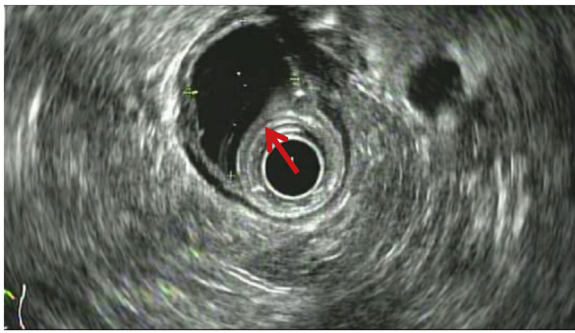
Endosonographic appearance of the anechoic cystic lesion (arrow) in the submucosal layer with well-defined outer sonographic borders.
